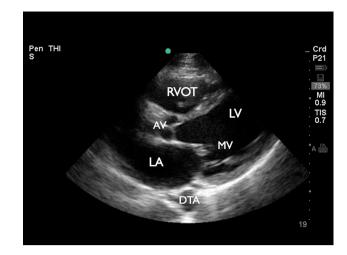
Poor left ventricular ejection fraction. This parasternal long view of the heart was obtained by placing the phased array probe to the left of sternum at approximately the fourth intercostal space with the indicator pointed toward the patient's right shoulder. The left atrium (LA), mitral valve (MV), left ventricle (LV), aortic valve (AV), right ventricular outflow tract (RVOT), and descending thoracic aorta (DTA) are all seen in this image. This parasternal long view demonstrates poor left ventricular systolic function as evidenced by minimal inward movement of the walls of the left ventricle and significantly diminished excursion of the anterior leaflet of the mitral valve. [See Supplemental Video 3]
